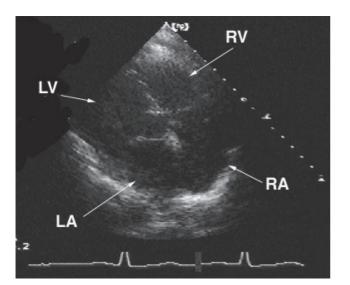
Four chamber view of the Echocardiogram showed normal chamber size and good function. Chambers are labeled in the lower picture and orientation is the same in subsequent images.
